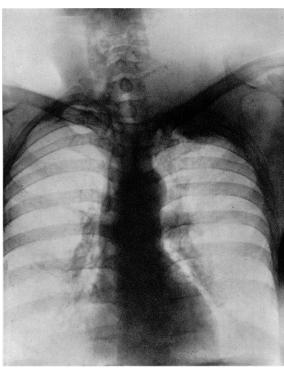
Radiograph of chest, September 15, 1937. Note erosion of seventh cervical vertebra and disappearance of first and part of second left ribs.
